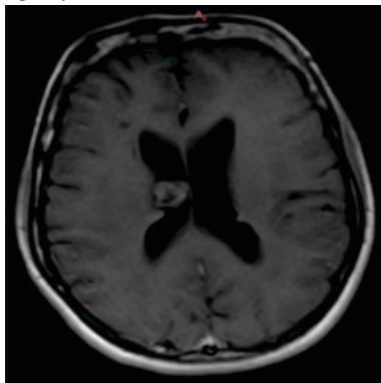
MRI, Axial FatSat contrast enhanced image showing Subependymal nodule along the wall of right lateral ventricle.
